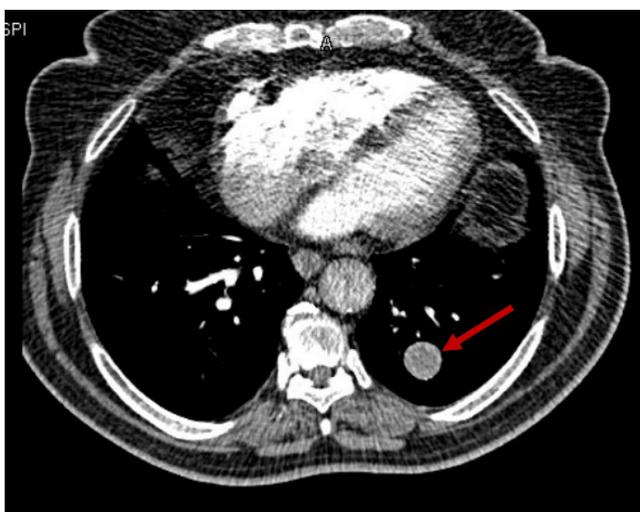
CT Chest indicating left lower lobe pulmonary nodule (arrow).
